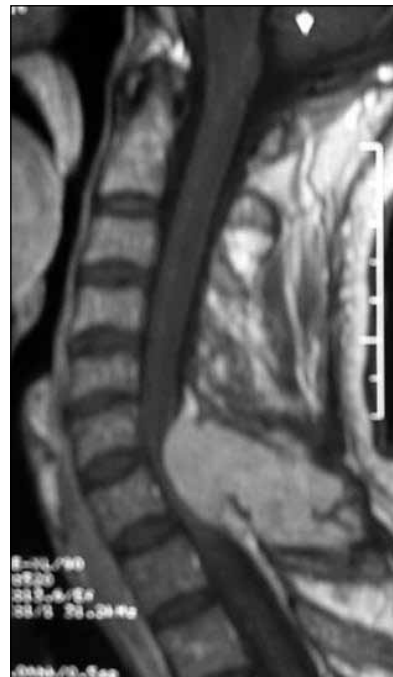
T1-weighted image of contrast-enhanced magnetic resonance imaging (MRI) showed lobulated mass that extended superiorly and inferiorly between C6-Th2 vertebral levels.
